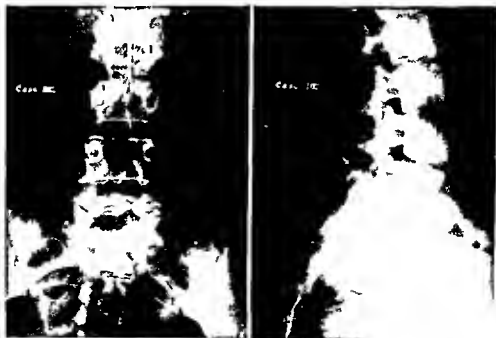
Roentgenograms of Case 3 of isthmus. (See operative findings.) Traumatic lesions
